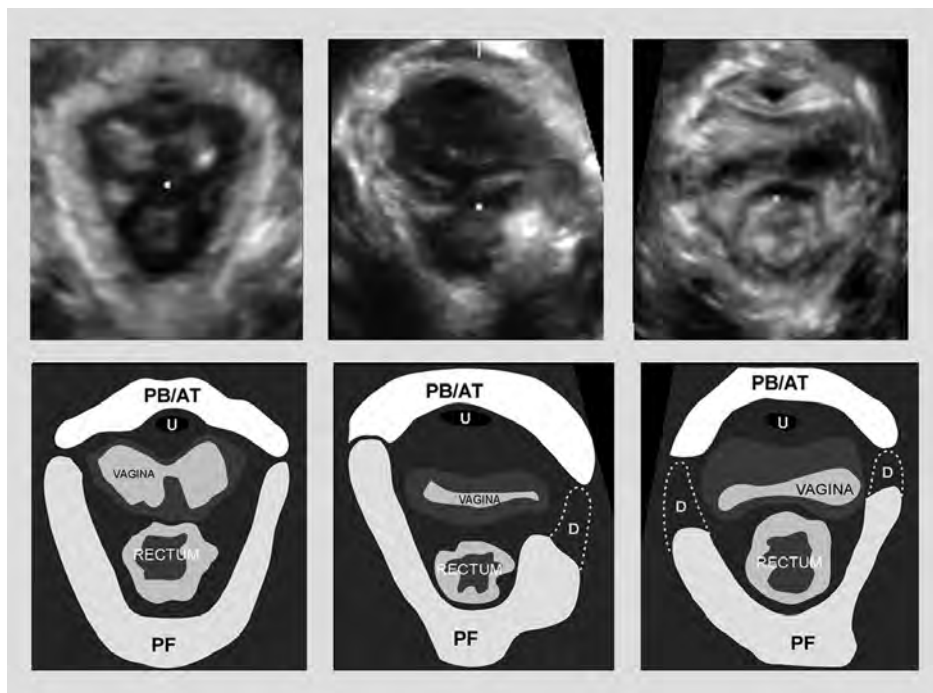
Transperineal ultrasound of the pelvic floor
